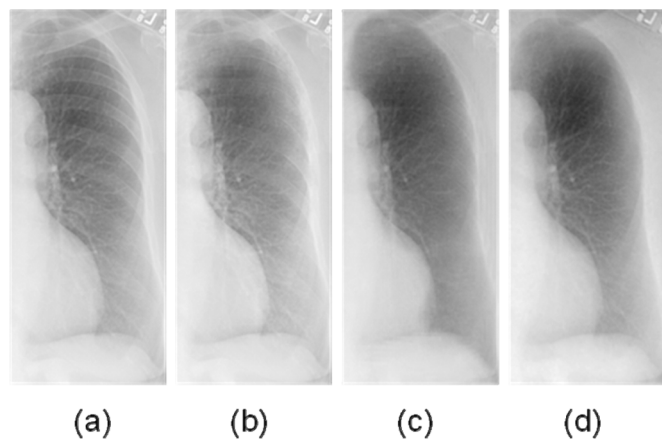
Result for a nontraining normal chest radiograph. (a) An original normal chest radiograph, (b) a VDE soft-tissue image obtained by use of our original MTANN technique, (c) a VDE soft-tissue image obtained by use of our new MTANN technique, and (d) the corresponding “gold-standard” dual-energy soft-tissue image.
